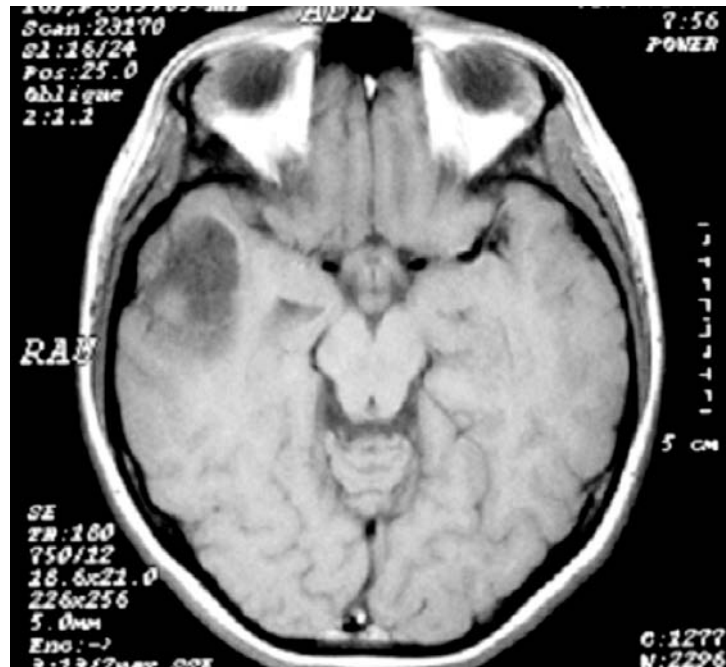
T1-weighted imaging with gadolinium enhancement MRI slice showing low-grade glioma which is partially hypo and partially isointense, occupying right temporal lobe with cortical presentation.
